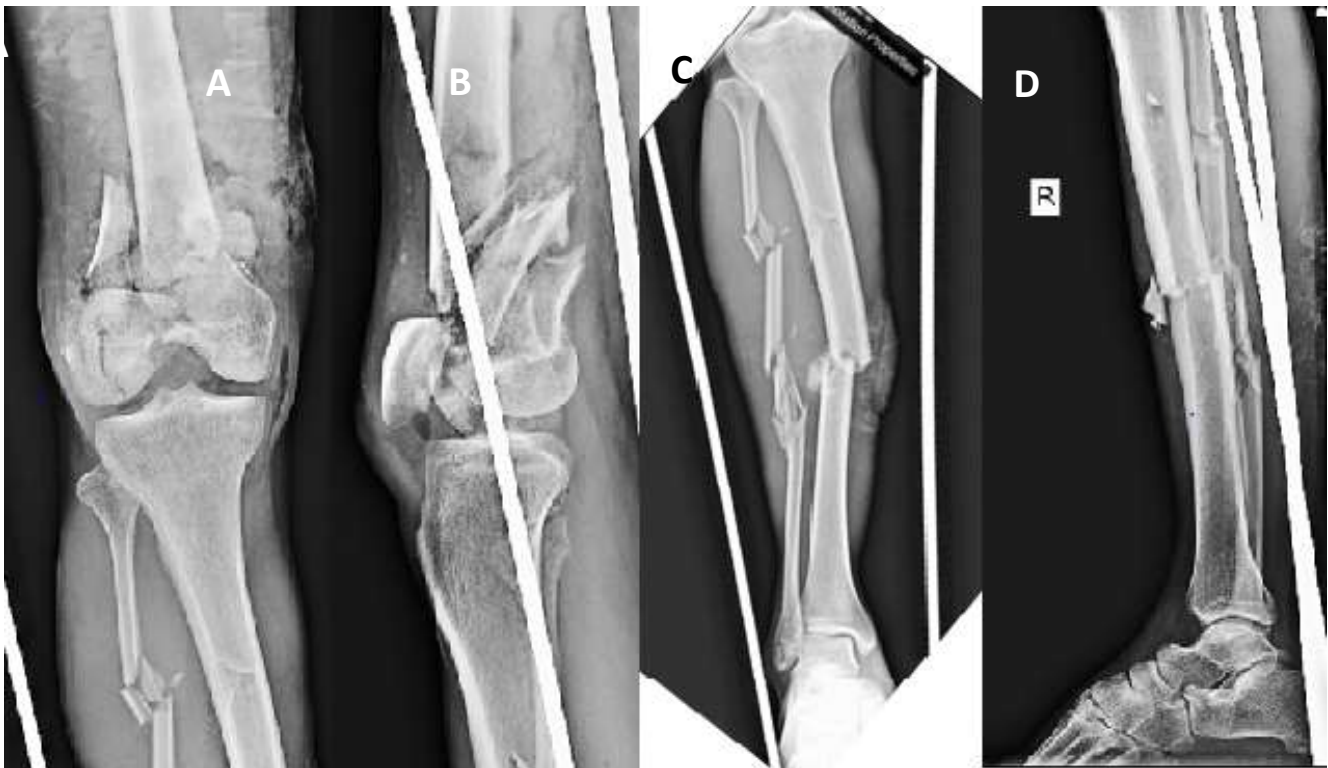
Pre-operative radiograph showing right knee with leg and ankle; A: Antero-posterior view showing comminuted displaced fracture of distal femur with intra-articular extension (AO type-33-C2.3); B: Lateral view showing comminuted displaced fracture of distal femur with patella subluxated posteriorly; C: Antero-posterior view showing mid-shaft tibia fracture with comminuted segmental shaft fibula fracture (AO type-42-C2); D: Lateral view showing mid-shaft tibia fracture with segmental shaft fibula fracture
